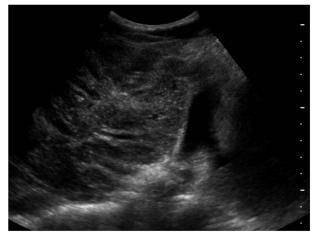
Ultrasound of the liver. Transverse image demonstrating left lobe with heterogeneous echotexture and moderate ascites.
